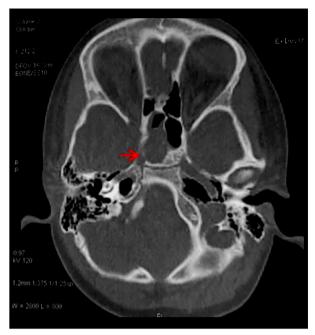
Axial computed tomography scan. The picture shows an expansive lesion in the right sphenoid sinus, causing cortical rupture in its posterior and lateral wall and extending to the intracranial compartment next to the right cavernous sinus. The size of the lesion was 1.5×1.2 cm.
